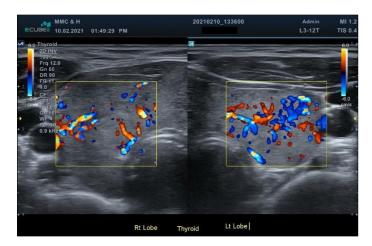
Thyroiditis. 30 years old female with swelling in midline neck shows enlarged and heterogeneous B/L lobes of thyroid with increased internal vascularity on color Doppler.
